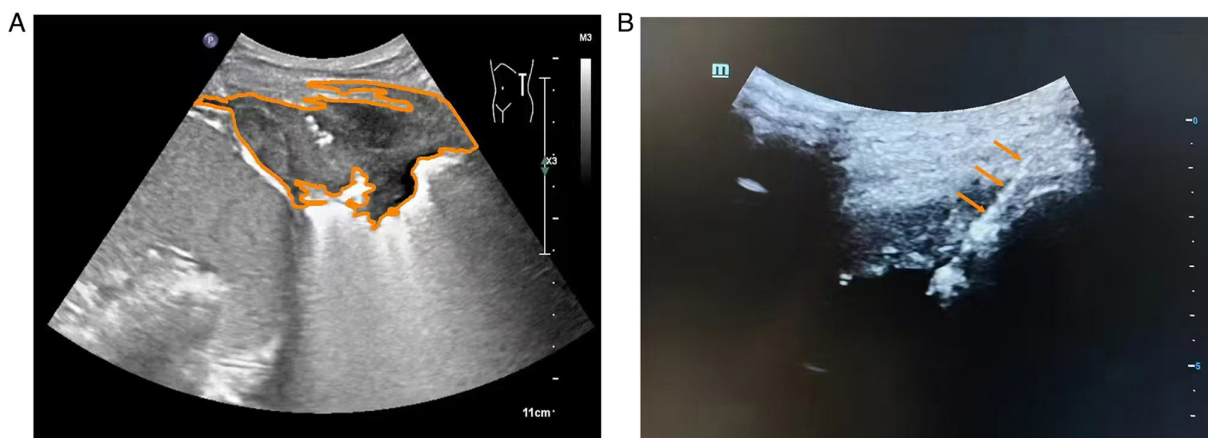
Ultrasound images. (A) Ultrasound imaging can clearly display pleural hypoechoic lesions, outlined by orange lines in the figure. (B) When performing biopsy on pleural lesions under ultrasound display, ultrasound can clearly show the biopsy needle (orange arrow).
